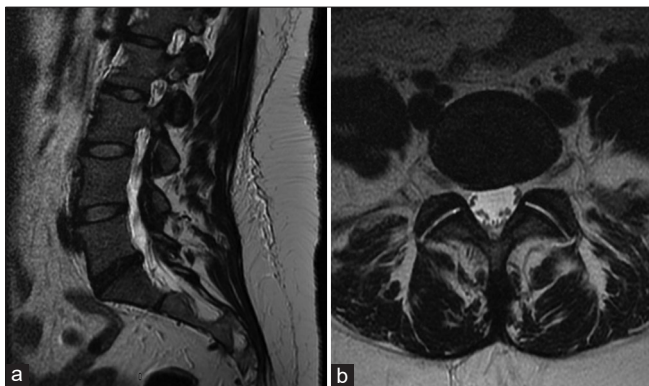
(a) Sagittal T2-weighted MRI image of the lumbar spine. (b) Axial T2-weighted MRI image of the lumbar spine.
